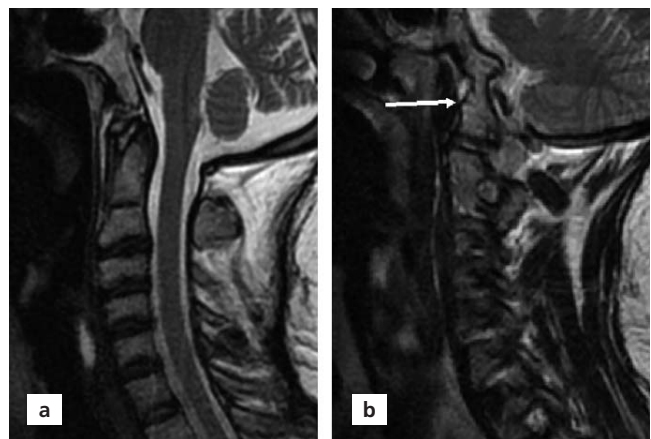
(a) A 48-year-old man with AOA. No bony fusion of anterior and posterior arches of the atlas with occipital condyle seen at mid-sagittal MR image, but there is severe atrophy of suboccipital muscles. (b) Parasagittal T2-weighted image shows a bony fusion of lateral body with occipital condyle (arrow).
